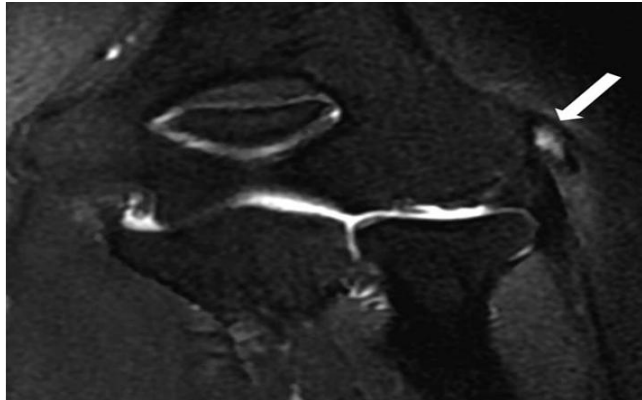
52-year-old man with left elbow pain 1.6 years (Tendinopathy score $\frac{1}{4}$ 2; PRTEE score $\frac{1}{4}$ 57). Coronal T2-weighted fat-suppressed MR image shows moderate focal increased signal in tendon (white arrow). PRTEE $\frac{1}{4}$ Patient-Rated Tennis Elbow Evaluation
